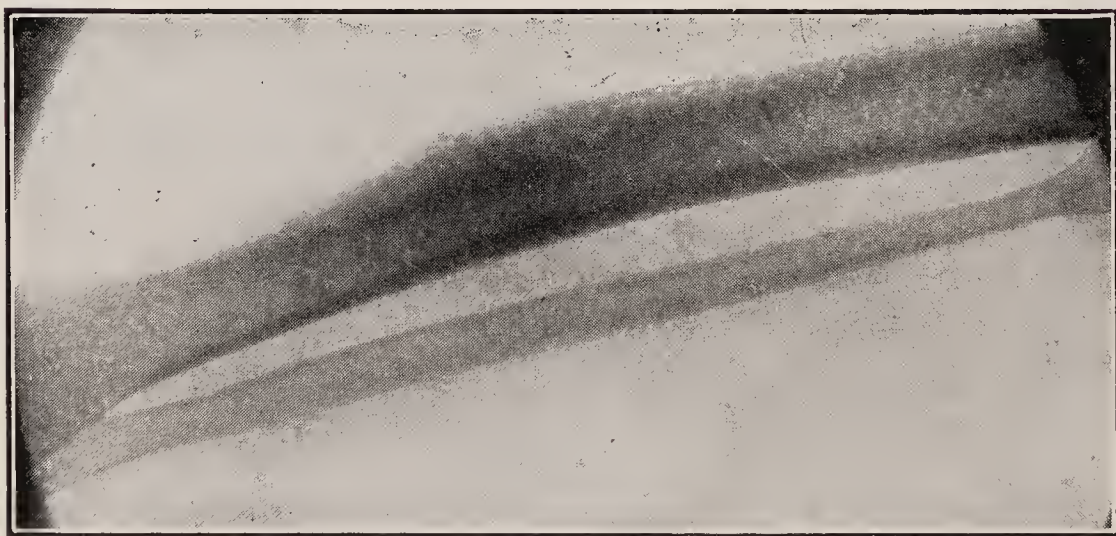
X-ray of sabre tibia.
